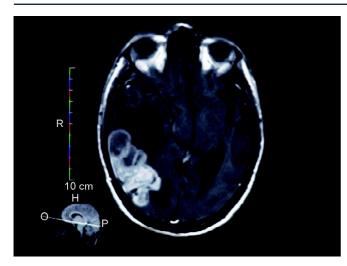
CT scan showing a dural based lobulated, enhancing lesion in temporoparietal region
